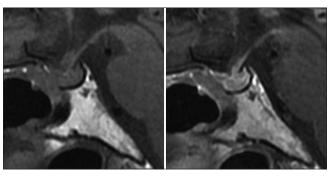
Magnetic resonance imaging after surgery. The postoperative series of magnetic resonance imaging I year after the surgery showed no progression of the lesion
